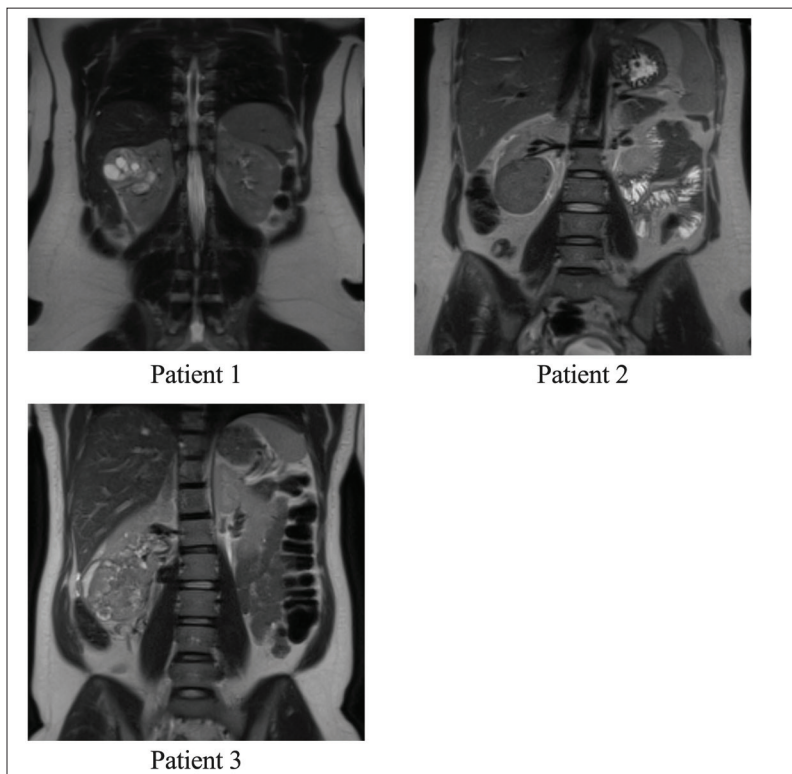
Preoperative staging non-contrast magnetic resonance imaging of all three patients (labeling per Table 1).
